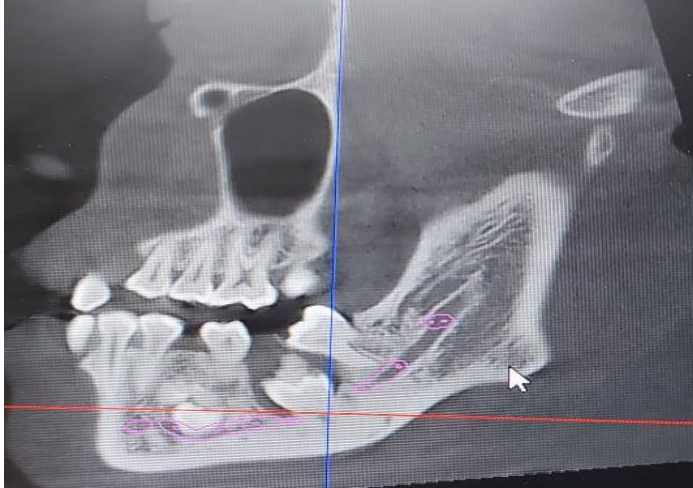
Coronal and sagittal sections of computed tomography depicting bilateral multiple large nonspecific, disorganised, irregular radio-opaque mass with varying densities, unable to be recognised as a dental tissue
